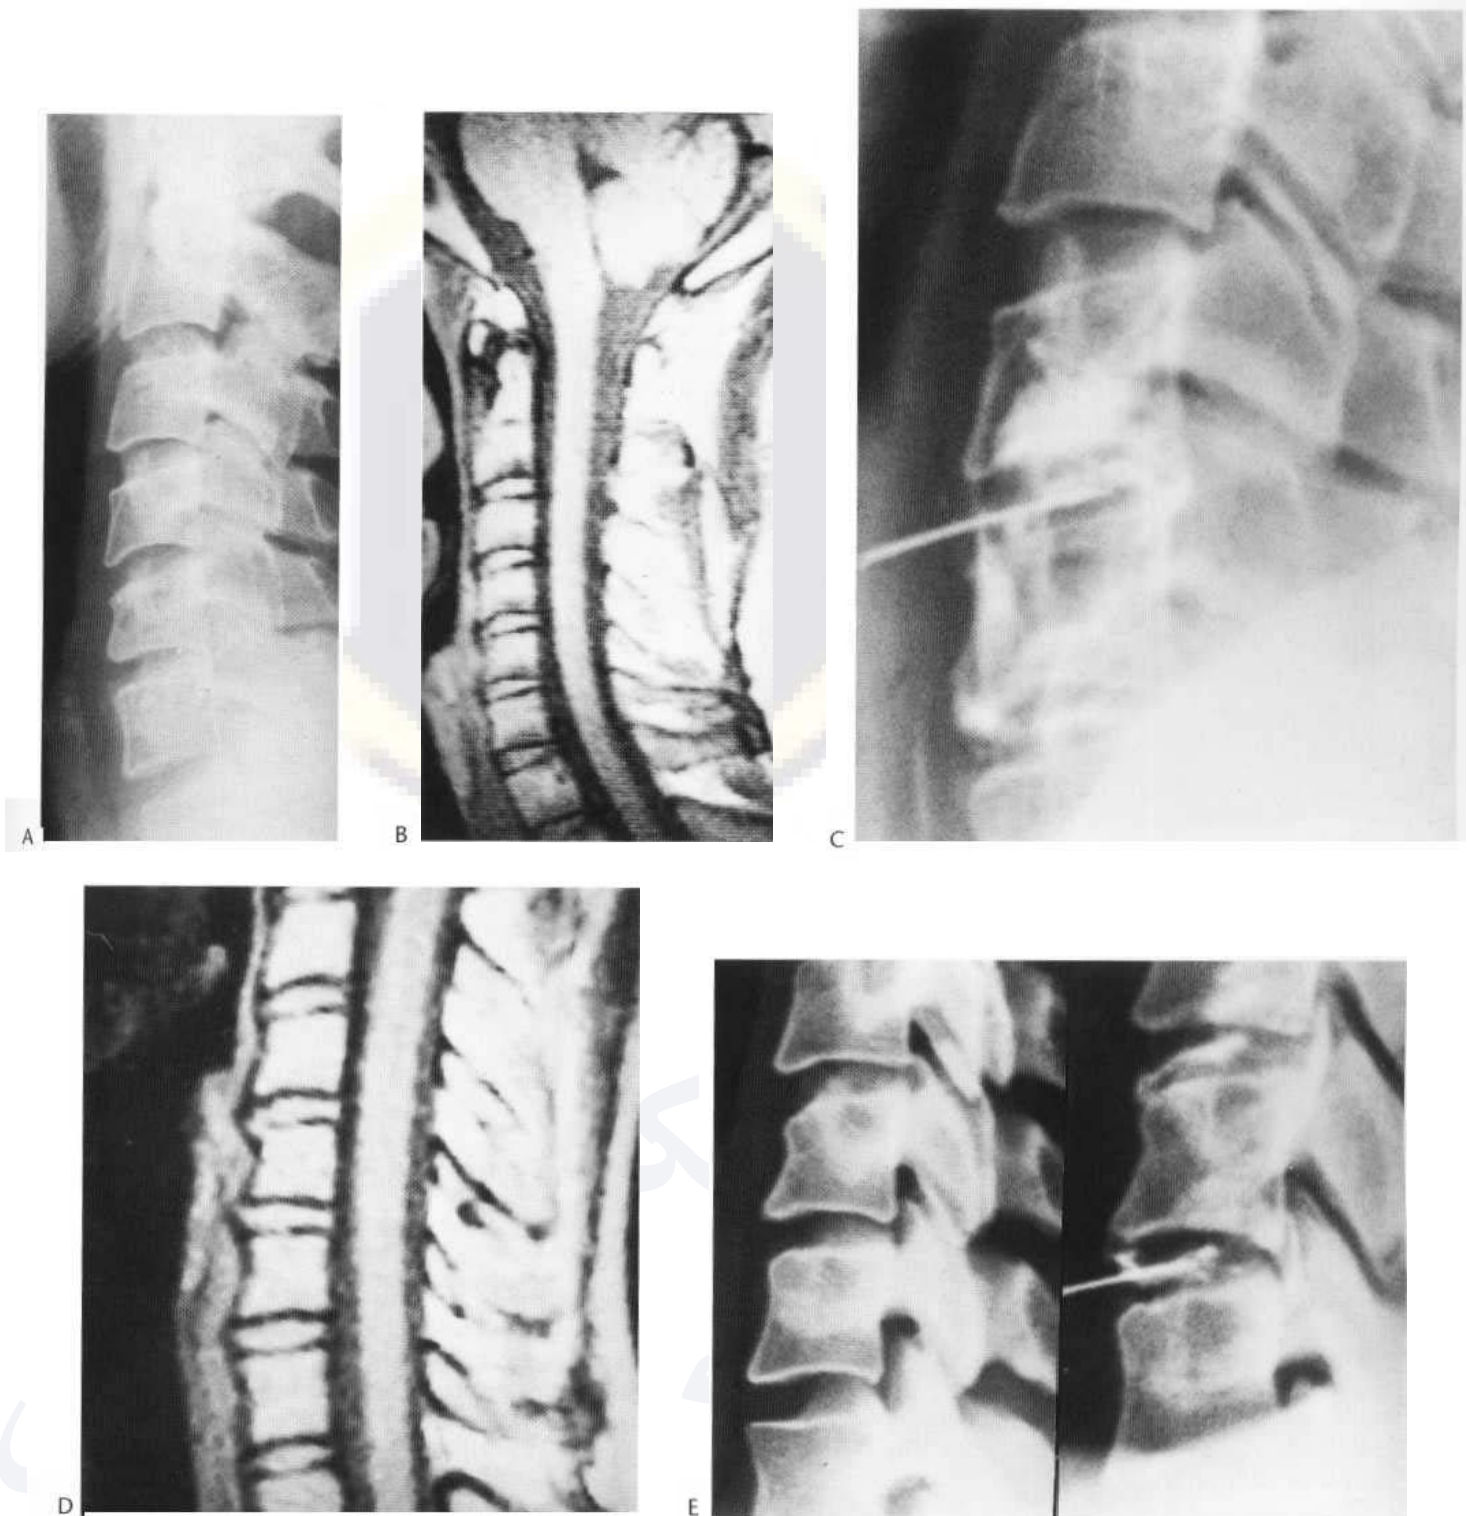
Early cervical spondylosis. (A) The plain film shows slight loss of the normal curve centered around the C5/6 disc which is also minimally narrowed. (B) A T2-weighted MR scan shows anterior discal bulging and marginal osteophytosis at the C4/5 and C5/6 levels. (C) A discogram confirms the presence of an annular tear with substantial leak of contrast. (D) Another T2-weighted MR scan. (E) A cervical discogram in a more advanced form. The MR scan is abnormal with anterior discal bulging and marginal osteophytosis at C4/5 and C5/6 levels. (E) In the discogram of the same patient anterior and posterior annular tears are demonstrated with dorsal bulging. The anterior annular tears are shown to extend to the osteophytes.
